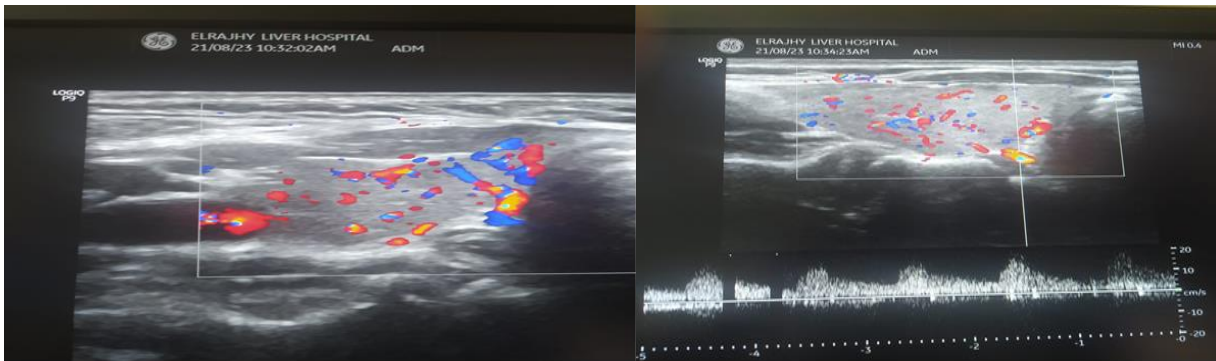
Another thyroid ultrasound with colour Doppler in patients with UC have 2 nodules in left and 1 nodule in right lobe 1 patient (1.3%) get total thyroidectomy with no recurrence.
